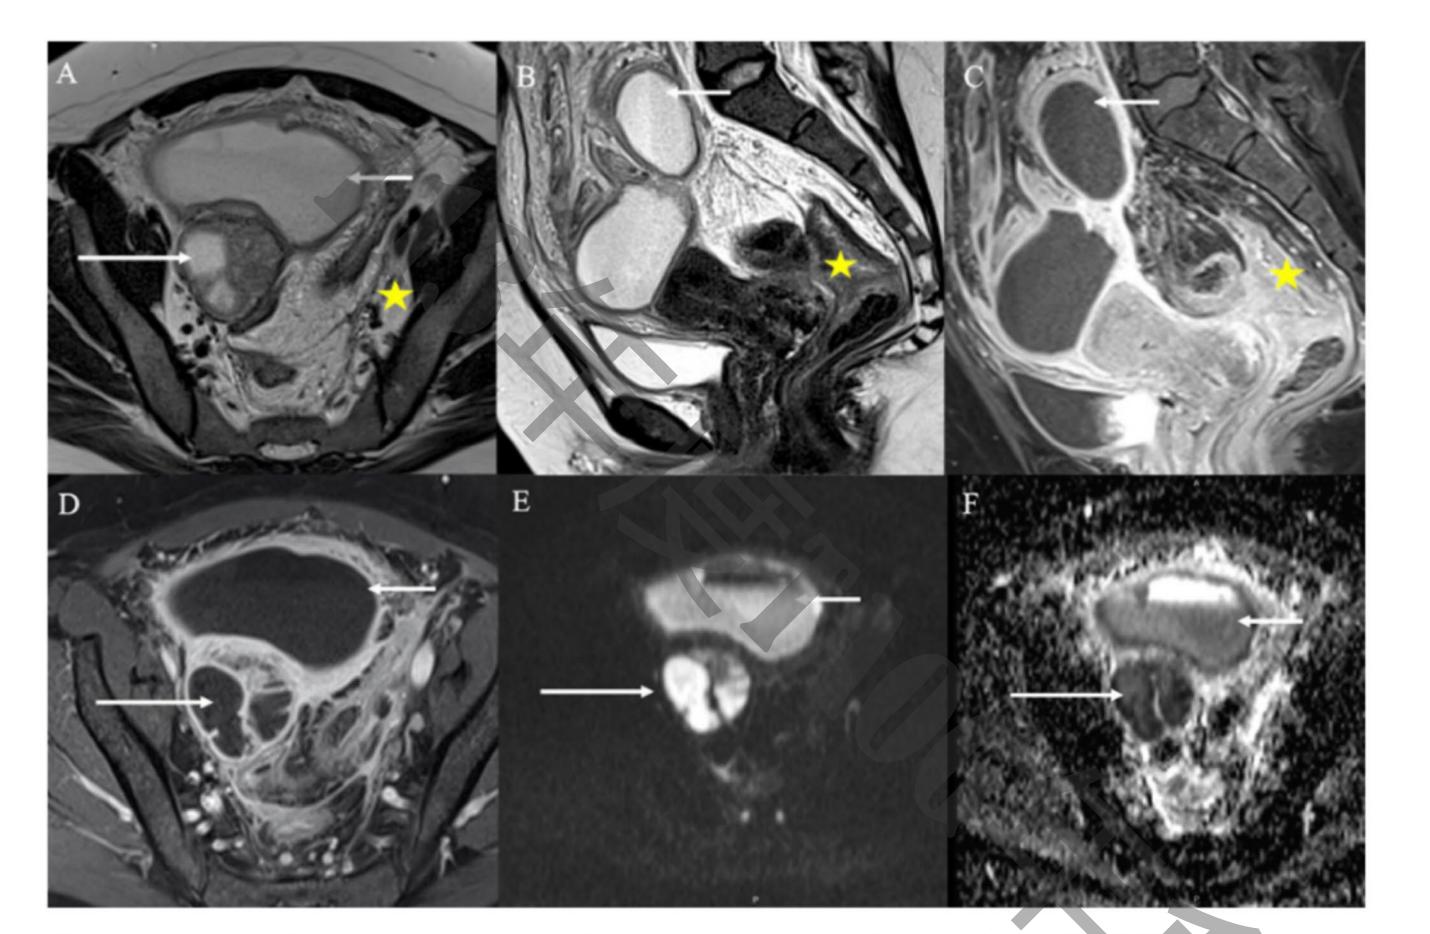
Pelvic magnetic resonance imaging (MRI) for further characterization, which shows a probably abdominopelvic abscess (short arrow) and a right tubo-ovarian abscess (long arrow). The surrounding inflammatory changes are indicated with stars. (A) Axial T2-weighted. (B) Sagittal T2-weighted. (C) Sagittal T1-gadolinium. (D) Axial T1- gadolinium. (E) Diffusion-weighted images (DWI) B value 1000 mm³/s. (F) Attenuation diffusion coefficient (ADC)
